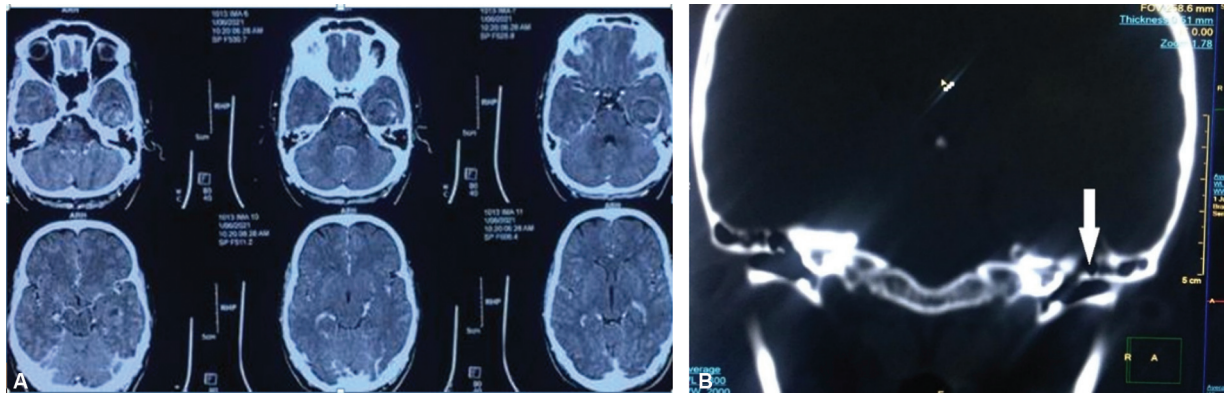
(A) Contrast-enhanced computed tomographic scan of brain showing well-defined extra-axial lesion in left middle cranial fossa, with heterogeneous enhancement and (B) erosion of the anterior superior surface of the petrous bone (the course of greater superficial petrosal nerve, white arrow).
